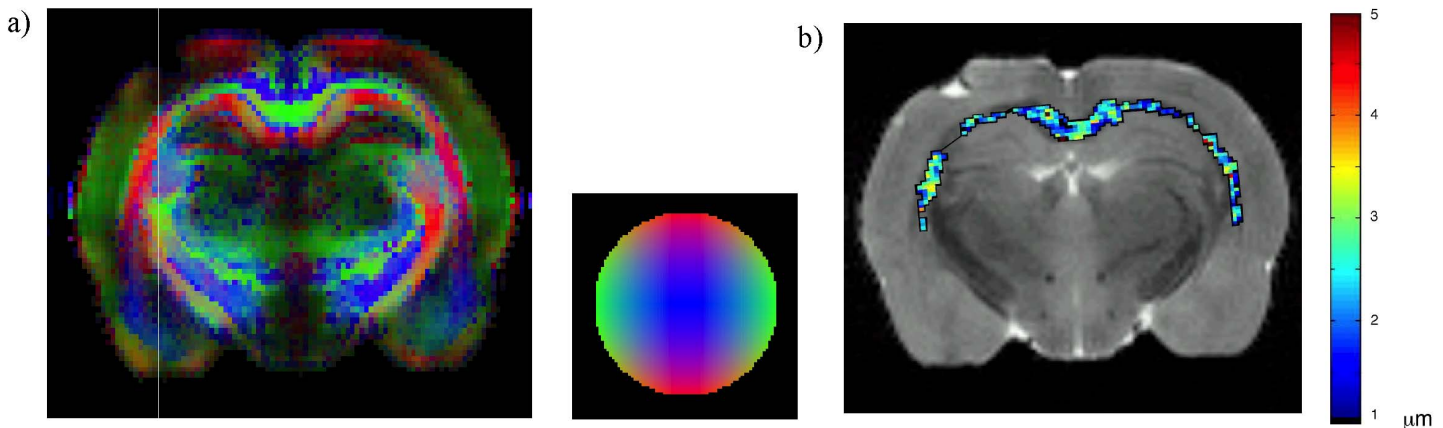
a) Direction-encoded color (DEC) map obtained from an independent DTI acquisition showing the fiber orientation. b) Average fiber diameter map (color) computed from d-PFG filtered MRI experiment overlaid on a non-diffusion weighted d-PFG image (grayscale).
